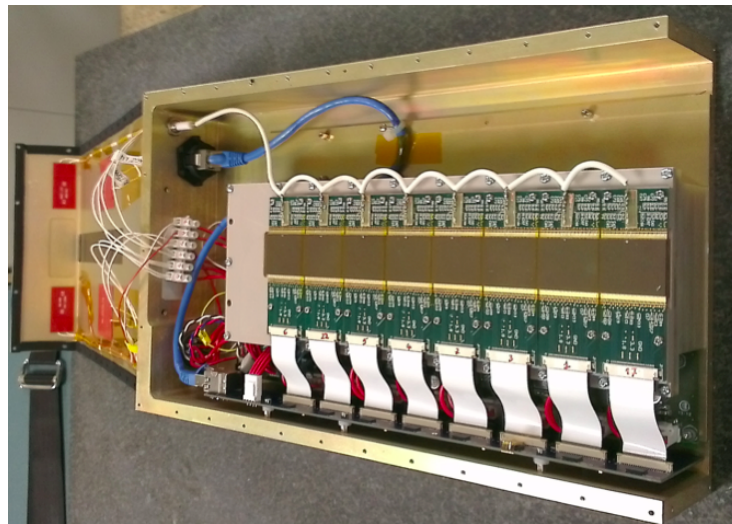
PIXIRAD-8 CdTe unit: count rate > 30 GHz, high efficiency in the energetic range of SYRMA-CT (30 - 40 keV), "noiseless" (a low threshold of 2 keV), readout at 30 frames/s.
